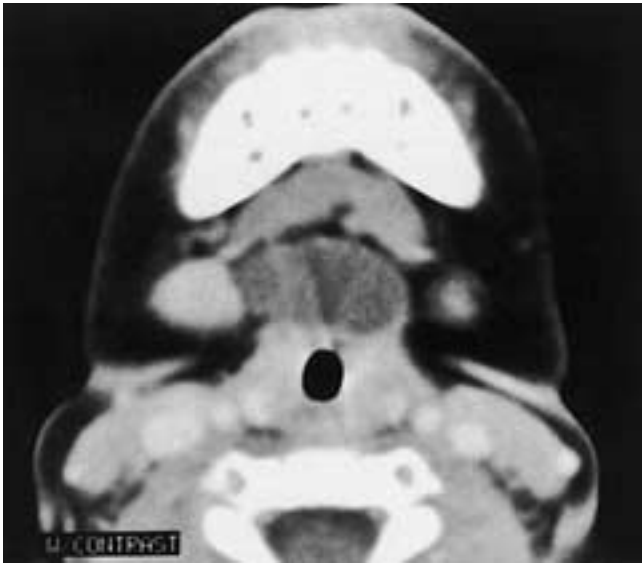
Thyroglossal duct cyst in a 1-year-old infant with a soft midline neck mass. Contrast-enhanced CT shows a low-density, nonenhancing unilocular midline mass in the midline floor of the mouth.
